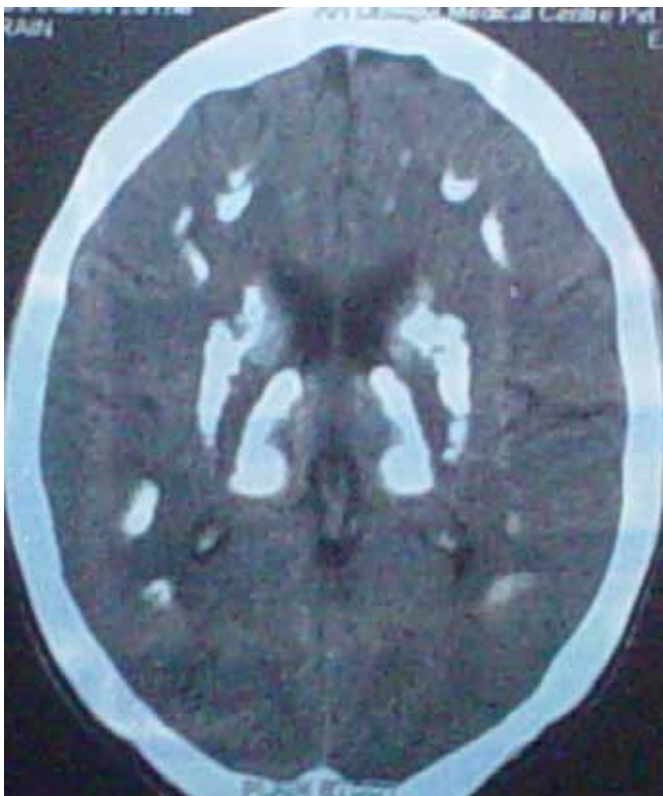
CT scan of Brain of the proband showing bilateral basal ganglia and subcortical calcification.
